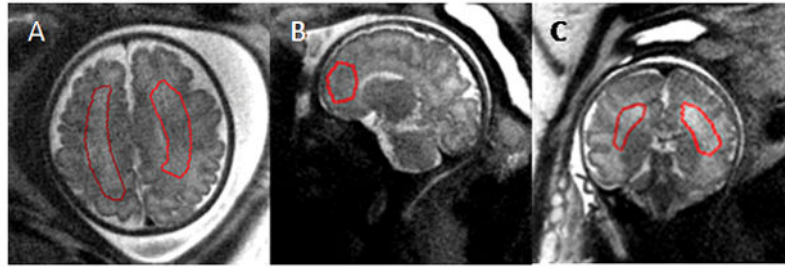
Placement of the ROI on T2 MRI datasets. ROIs were drawn on data acquired in three orientations for SNR measurements. Gestational age (weeks) A: 34 1/7; B: 34 4/7; C: 22 3/7. Images shown were acquired at 3.0T field strength.
